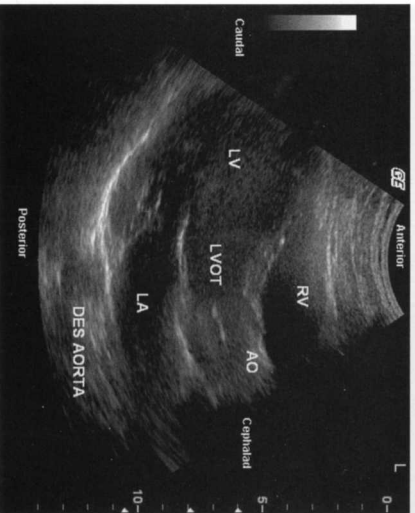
Normal parasternal, long-axis window. RV=right ventricle, LV=left ventricle, LVOT=left ventricular outflow tract, AO=aorta, DES AORTA=descending aorta.
